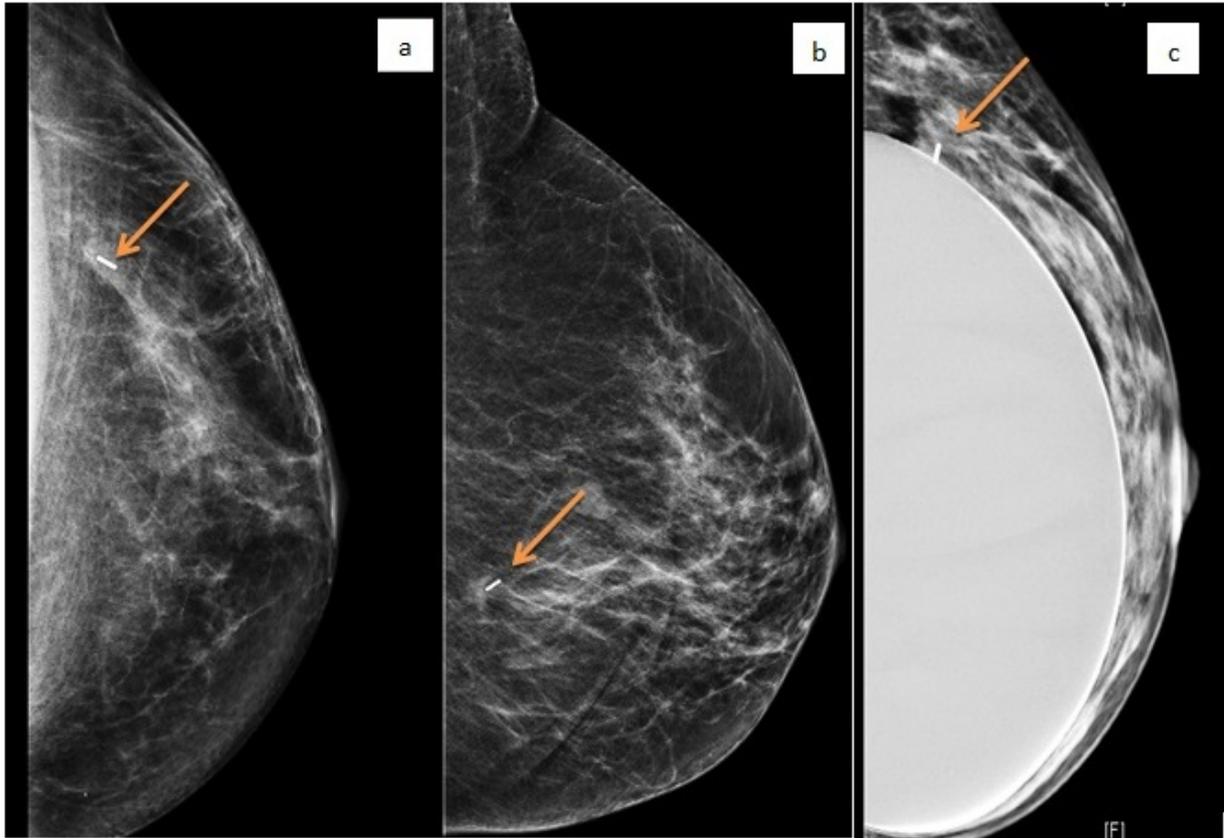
Magseed localization performed under mammographic (a) or ultrasound (b-c) guidance, even in case of prosthetic implant (c).
